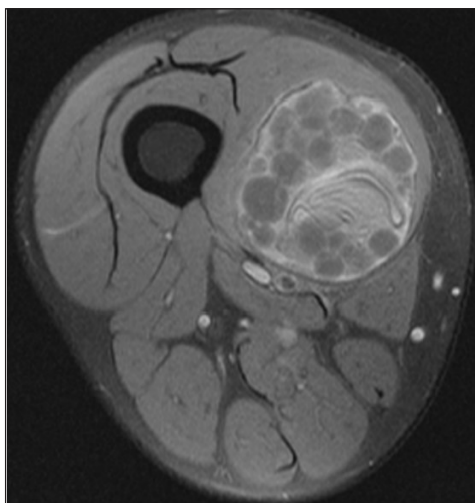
Coronal T2-weighted SPAIR and Fig 6D: Axial post-contrast fat sat T1-weighted turbo spin-echo MR images, one year after the treatment, a decrease in lesion size and the detached endocyst (black arrows) are seen
